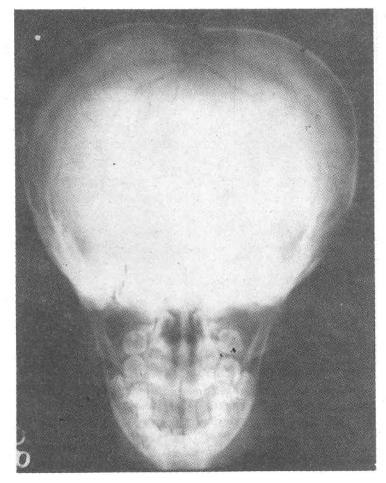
X-ray skull (lateral) showing widely open sutures and wormian bones
